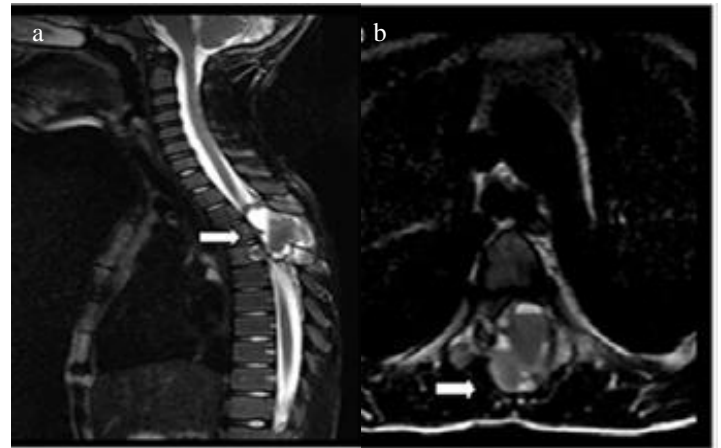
Sagittal (a) and axial (b) spinal MRI show a large cystic lesion arising from posterior parts of vertebrae with fluid levels causing prominent mass effect to the spinal cord at T4-5 level.
